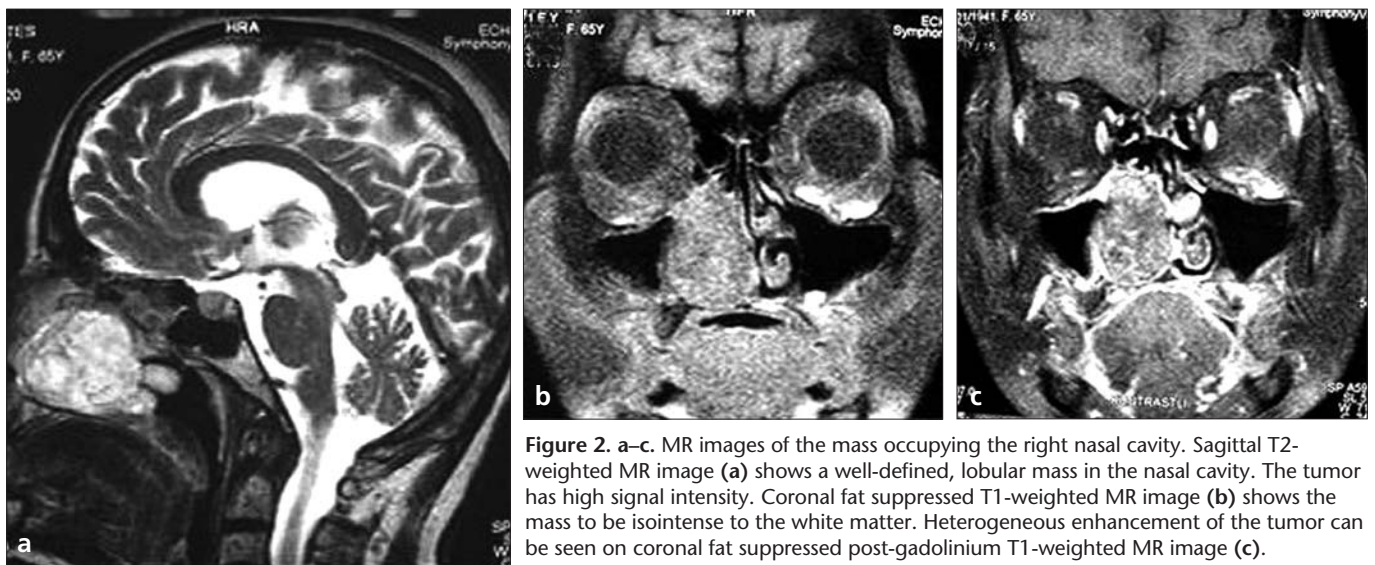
a-c. MR images of the mass occupying the right nasal cavity. Sagittal T2-weighted MR image (a) shows a well-defined, lobular mass in the nasal cavity. The tumor has high signal intensity. Coronal fat suppressed T1-weighted MR image (b) shows the mass to be isointense to the white matter. Heterogeneous enhancement of the tumor can be seen on coronal fat suppressed post-gadolinium T1-weighted MR image (c).
